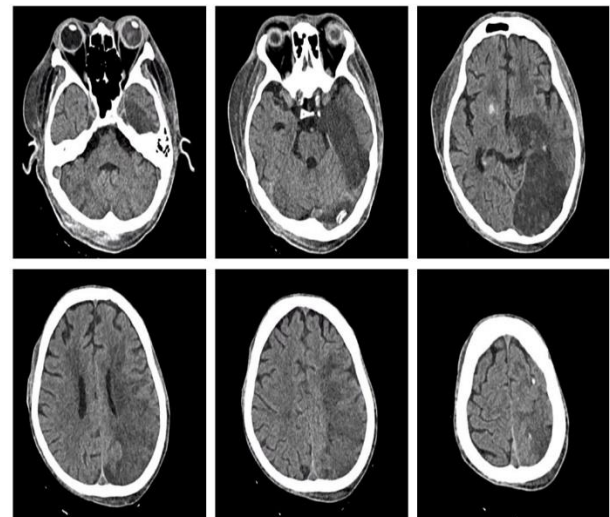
Brain CT demonstrating multifocal embolic ischaemic lesions in the left temporo-occipital, thalamic, and caudate regions (MCA and MCA/PCA territories), superimposed on chronic ischaemic changes in the bilateral centrum semiovale and an encephalomalacic cyst in the right occipital lobe.
